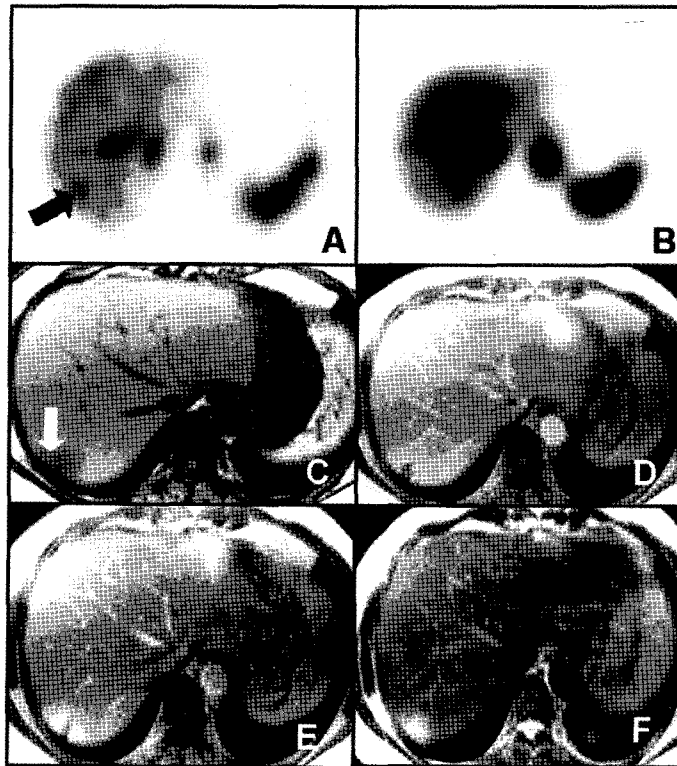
Only OSEM image (A) represents focal hot uptake (arrow) on segment 7. FBP failed to depict the same lesion (B). MR images show typical finding of hemangioma at segment 7 (C-F).
